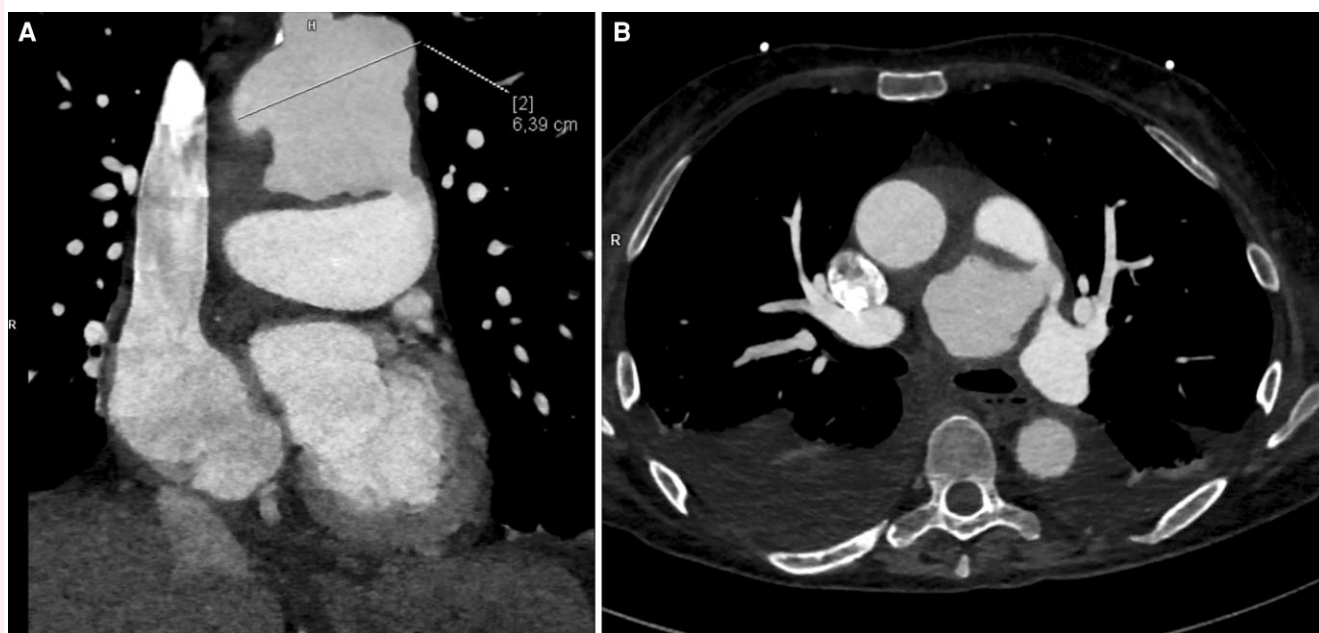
Two-dimensional CT angiography of the aorta demonstrates a small fistulous tract between the aortic arch aneurysm and the pulmonary trunk. Coronal Plane in Panel A and Axial Plane in Panel B.
